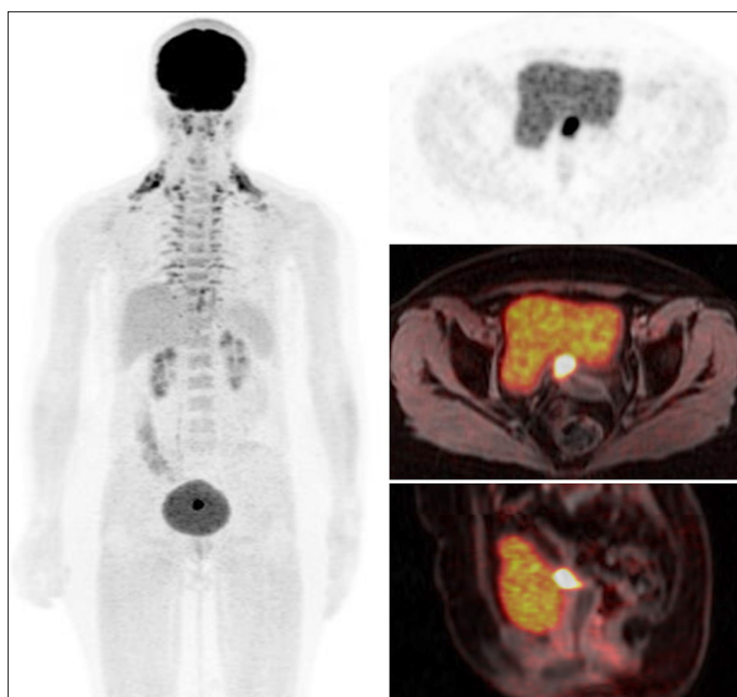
Coronal MIP PET and axial slices of T1-weighted PET/MRI sequences. A 46-year-old female patient with a history of cervical cancer treated with surgery and radiation therapy, underwent local recurrence investigation. A PET/MRI scan shows local recurrence in irregular lesions with increased glycolytic metabolism in the retrovesical region, near the vaginal dome. The case shows a potential benefit of using PET/MRI for the evaluation of gynecological neoplasias.
